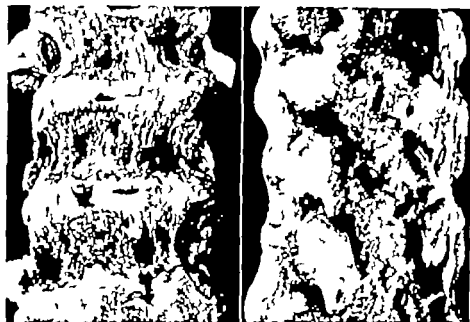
Osteosclerosis in chronic fluorine poisoning. Roentgenogram of the sternum (After Hultén.)
